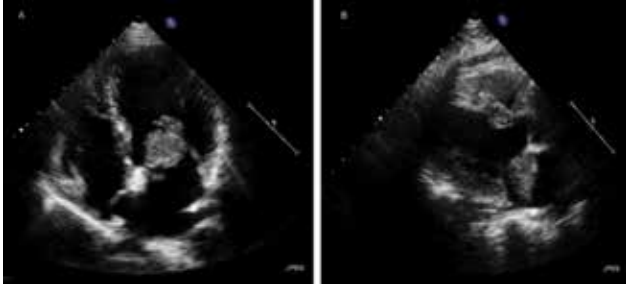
Transthoracic long-axis and four chamber two-dimensional echocardiographic images revealing a pedunculated tumor on the atrial side of the anterior mitral leaflet, prolapsing into the left ventricle during diastole (A) and into the left atrium during systole (B).
